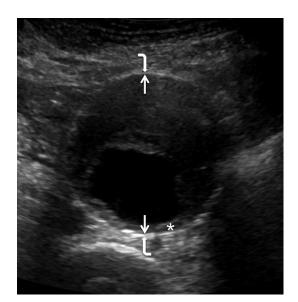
Transverse ultrasound image of an AAA. The aortic diameter is measured in the AP plane. The straight arrows indicate the position of the inner anterior and inner posterior wall. The angled arrows indicate the position of the outer anterior and outer posterior wall. The asterisk indicates an area of mural thrombus on the posterior wall
